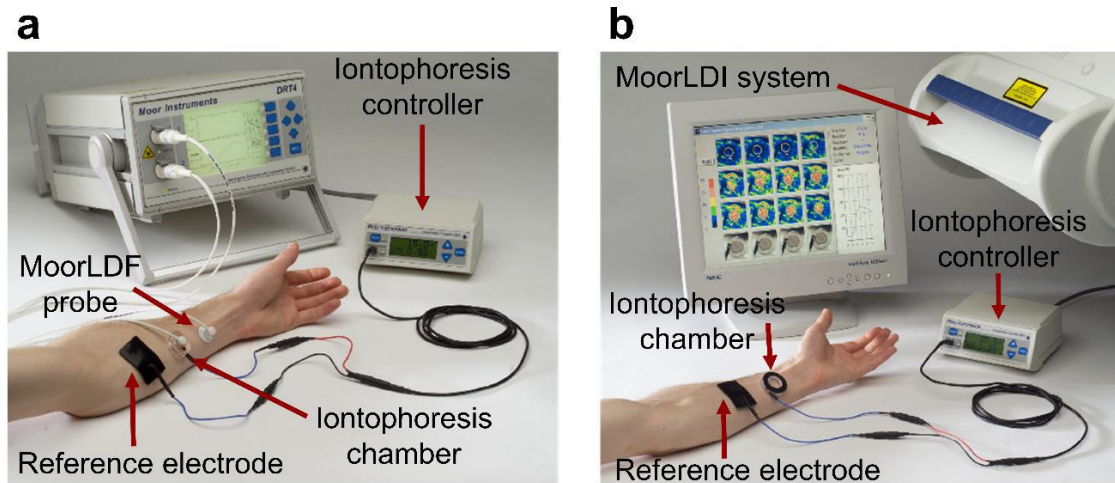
Laser Doppler iontophoresis equipment
